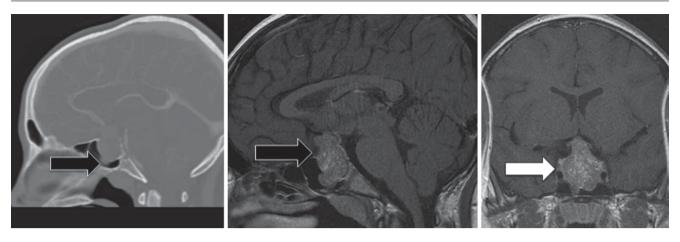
Radiographic appearance of pituitary macroadenoma. a Sagittal CT demonstrates erosion of bone at base of lesion into the sphenoid sinus (*black arrow*). b Same lesion seen on sagittal T1-weighted MRI
